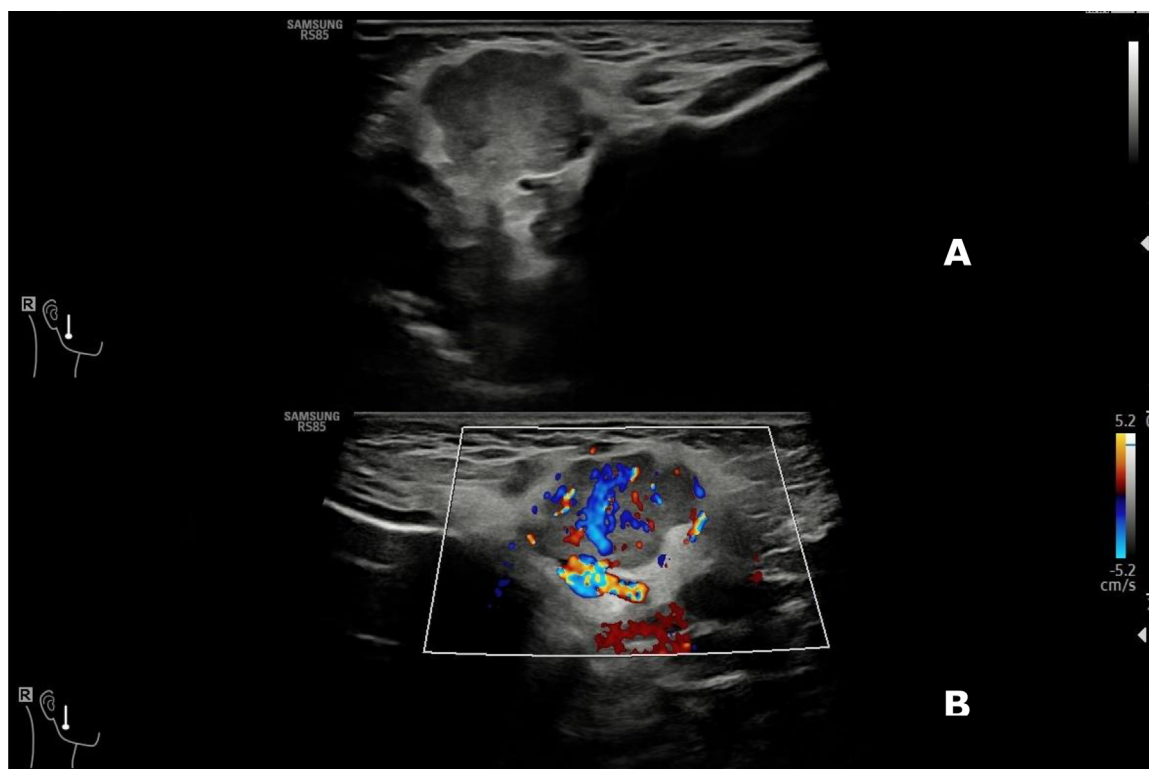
(A) Another smaller formation with the same ultrasound characteristics. (B) Multiple and coarse vessels prominent with marked vascularization at the evaluation with color Doppler in the context of the smaller formation.
